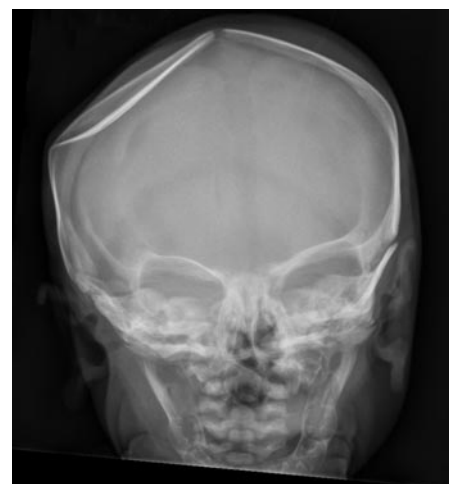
X-ray delineation of the skull deformity.
